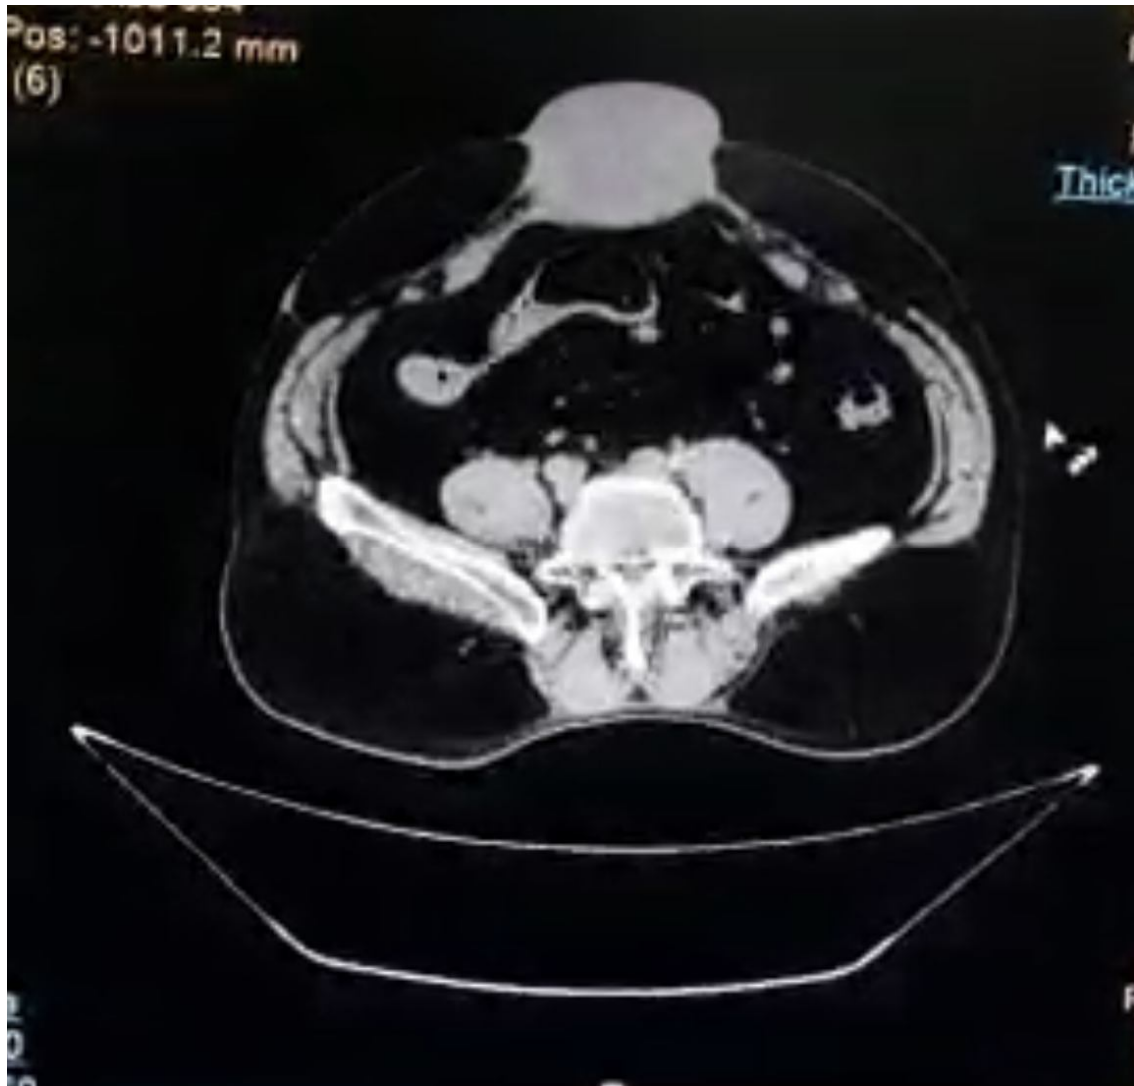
A contrast enhanced CT scan showing a single, well-demarcated lesion arising from the anterior abdominal wall devoid of any intra abdominal involvement.
